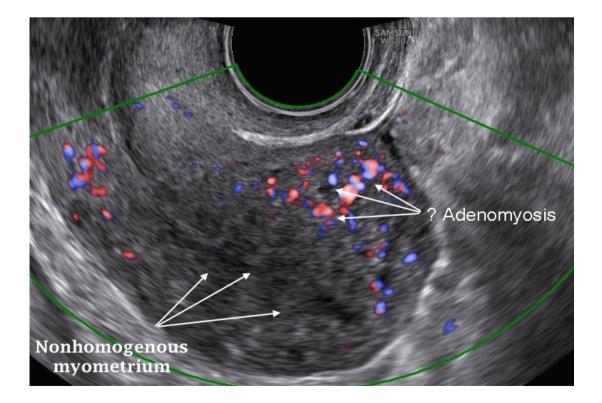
Ultrasound image of enlarged spheric shaped uterus with presumptive diagnosis of endometriosis
